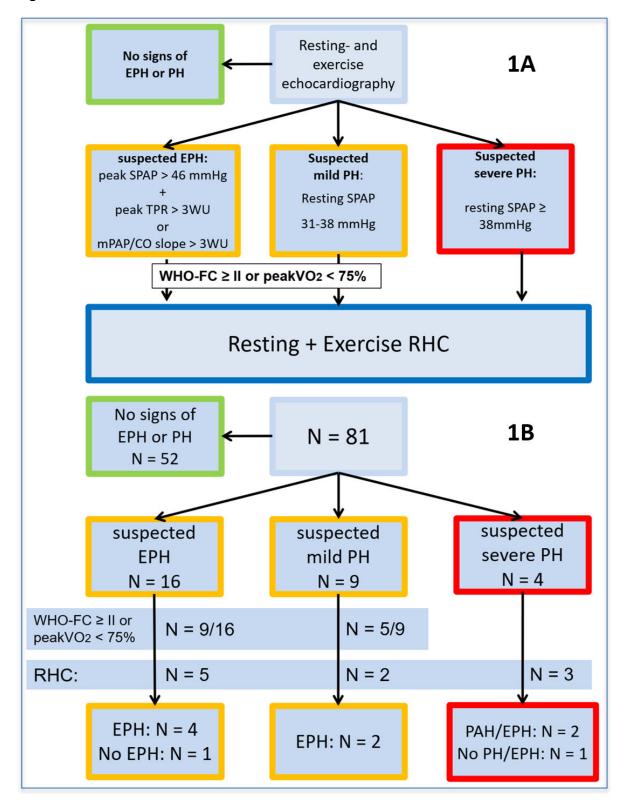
A: Screening algorithm for pulmonary vascular disease; Abbreviations: PVD: pulmonary vascular disease, PH: pulmonary hypertension, EPH: exercise pulmonary hypertension, mPAP: mean pulmonary arterial pressure; CO: cardiac output; sPAP: systolic pulmonary arterial pressure, WHO-FC: World Health Organization functional class, peakVO₂: peak oxygen uptake, RHC: right heart catheterization; B: Screening Results; Explanation: The light blue box represents the overall cohort. In 13 (16%) patients echocardiographic mPAP/CO slope could not be
